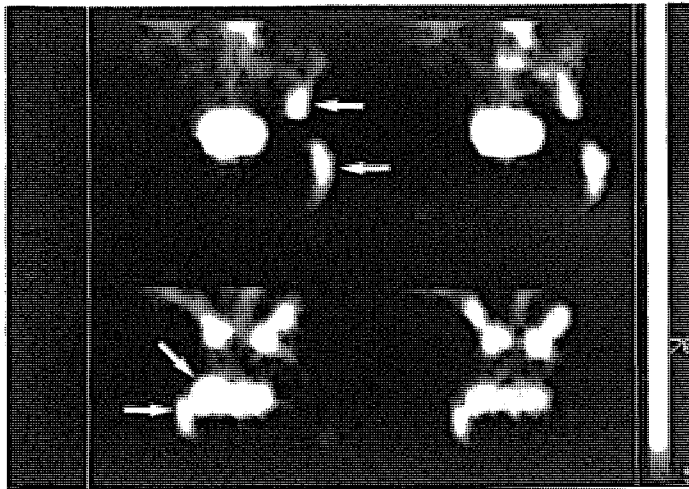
Coronal SPECT slices 6 h post injection: same patient as figure 2a.
